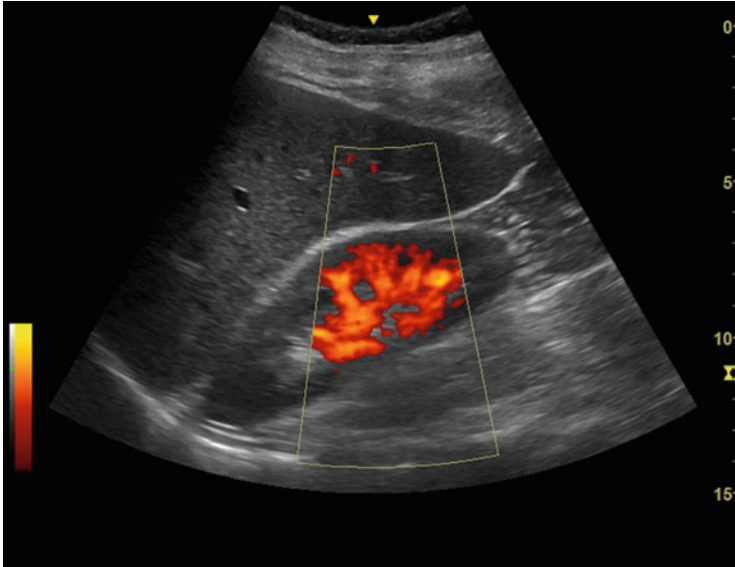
Power Doppler of a right kidney. The red, orange, and yellow areas represent the presence of blood flow with the sampled portion of the kidney
